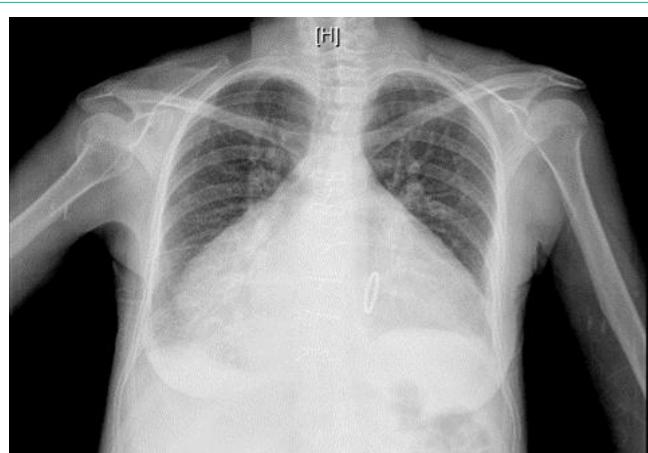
Chest radiograph showing biological valve prosthesis and markedly enlarged cardiac silhouette: antero-posterior view.
